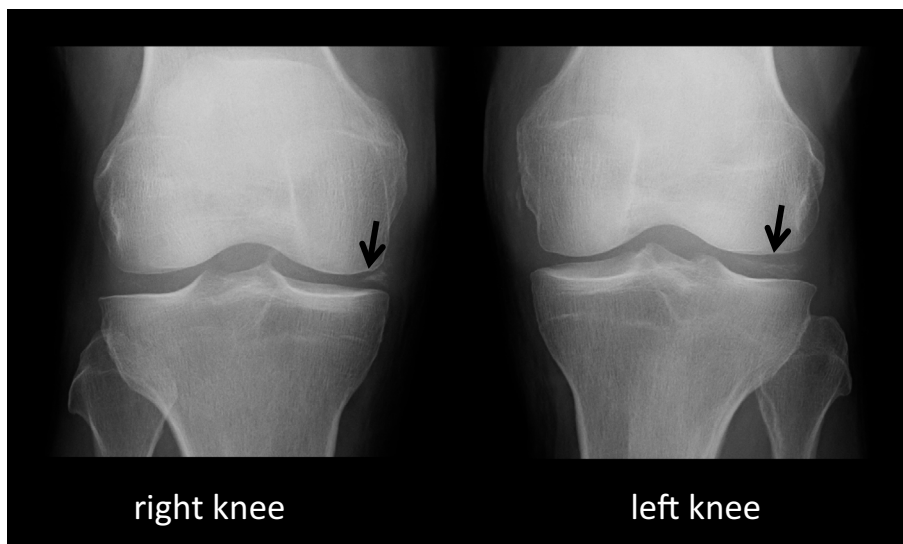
X-rays of both knees show calcification of the lateral meniscus of the right knee and the medial meniscus of the left knee.
